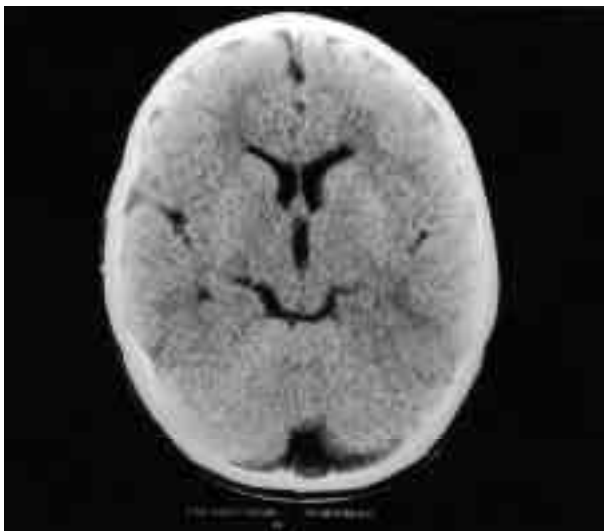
A normal cranial CT scan at the age of 9 months.
